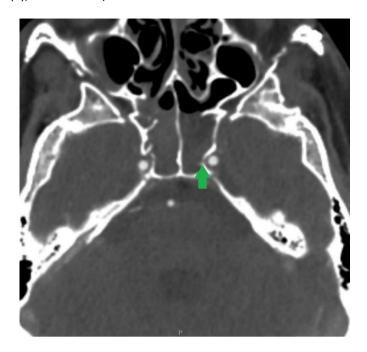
CT angiography, performed 4 days after trauma, revealing sphenoidal sinus wall fractures. No data of left internal carotid artery local posttraumatic lesion, October 2023, 4 days after the previous NECT.
